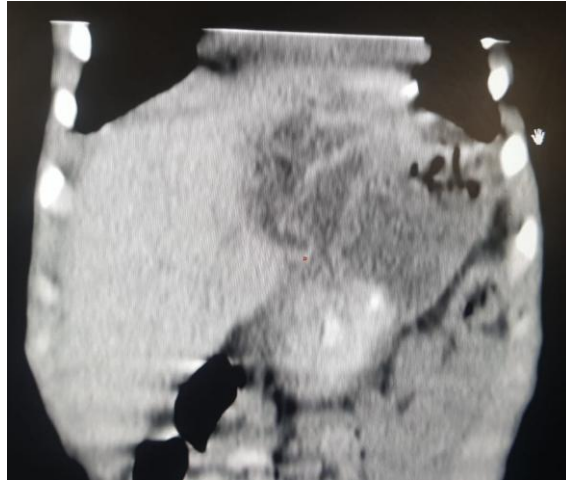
frontal cut of the abdominal CT showing the hepatic hydatid cyst
